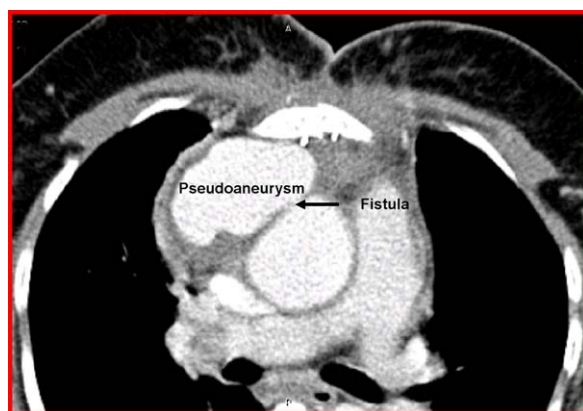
High resolution spiral chest CT scan (1 mm slice).
